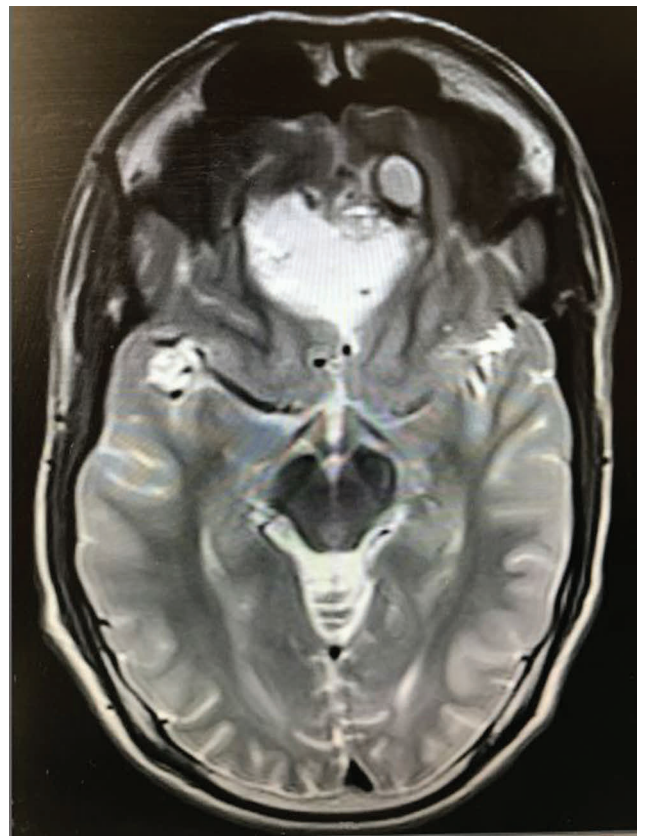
Axial MRI showing an interhemispheric epidermoid cyst.
